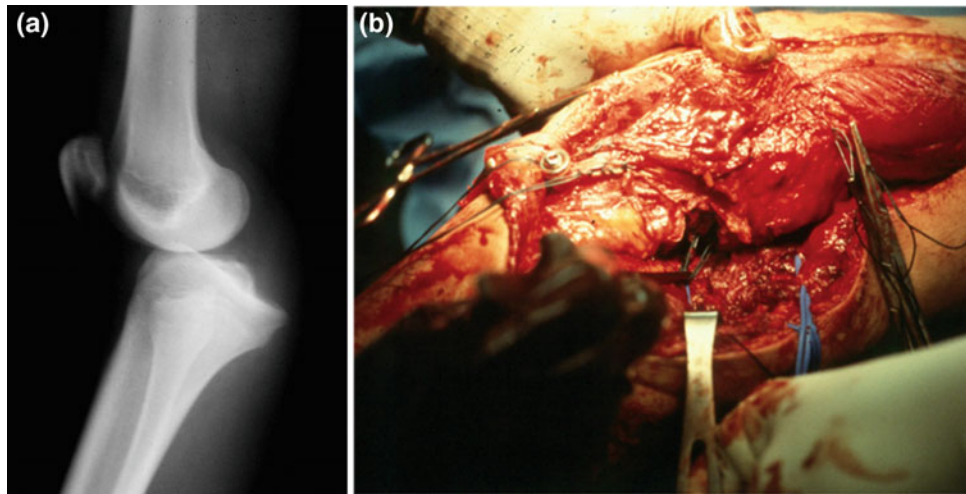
Lateral and only radiograph (a) available for patient with a KDIIMC that lead to the anatomic knee dislocation classification. The radiograph was not classifiable by the position system and appeared “perched”. Open exploration for the vascular injury related to the knee
